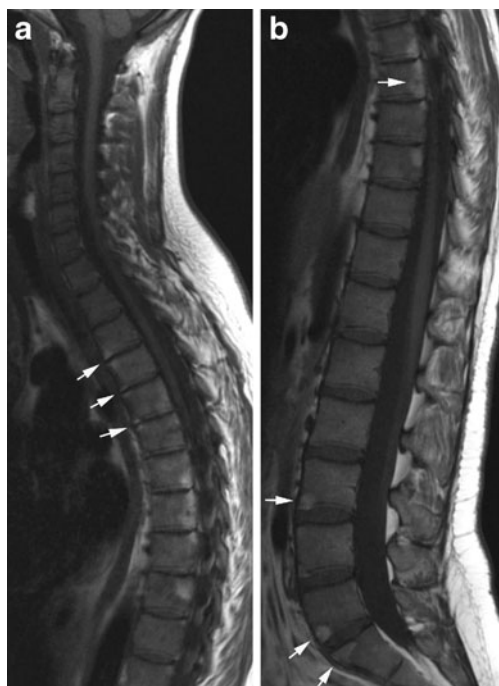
Chronic changes in AS by MRI. Sagittal T1 of (a) the cervicothoracic and (b) the lumbar spine of the patients shown in Fig. 10. There are multiple fatty marrow depositions at vertebral corners and also posteriorly in thoracic vertebral bodies (b, arrows). This was observed to have developed since the MRI performed 3 years previously (shown in Fig. 16 a–d) and corresponds to areas of previous inflammation
